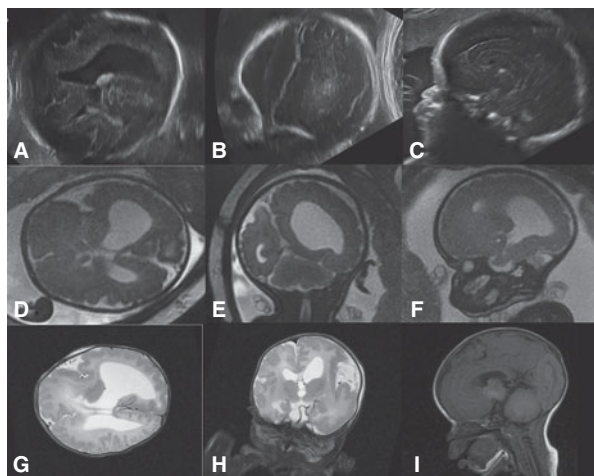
Hemimegalencephaly diagnosed by US at 28 postmenstrual weeks of gestation (A–C) with MRI confirmation at 29 weeks of gestation (D–F) and following delivery (G–I). The clinical course was complicated by refractory epilepsy. Note the difference in the size of the cerebral hemispheres and lateral ventricles. The corpus callosum is thick (C, I), and the vermis not observed in the midline (E, I). Abnormal sulcation in the left hemisphere is suggested on fetal images and clearly depicted in both hemispheres on postnatal MRI (G, H). (Courtesy of Dr. Mauricio Herrera, Bogotá, Colombia.)
